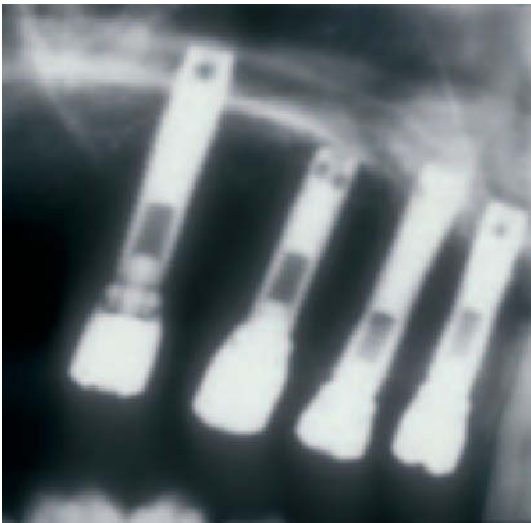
Postoperative radiograph showing demineralized bone graft. The implants seem to be without support.
